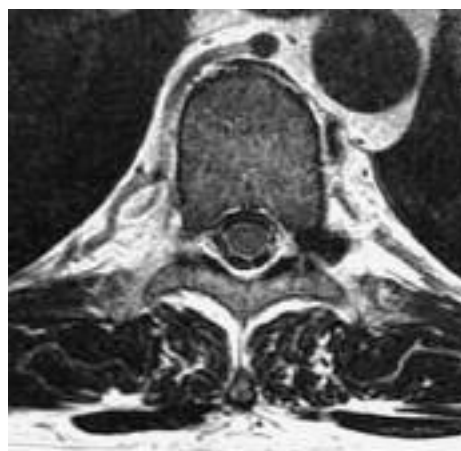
Preoperative axial MRI-scan of the lower thoracic spine, showing a “far lateral”, and more specifically an intraforaminal left Th9-Th10 disc herniation compressing the root of the 9th intercostal nerve.
